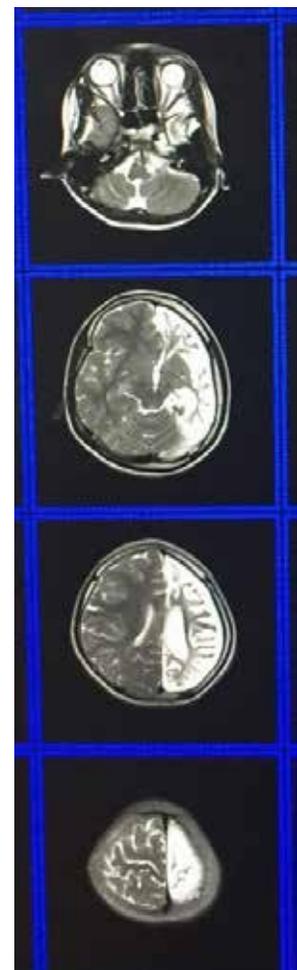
MRI brain showing atrophic hemiserebrum
